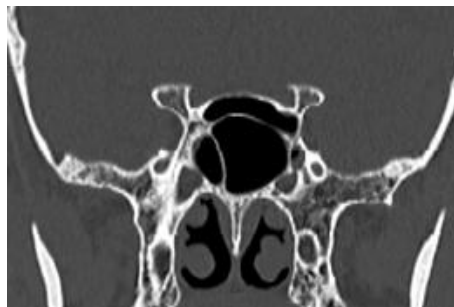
Coronal CT scan showing Onodi cell crossing the midline, and showing contact with both optic nerves.
